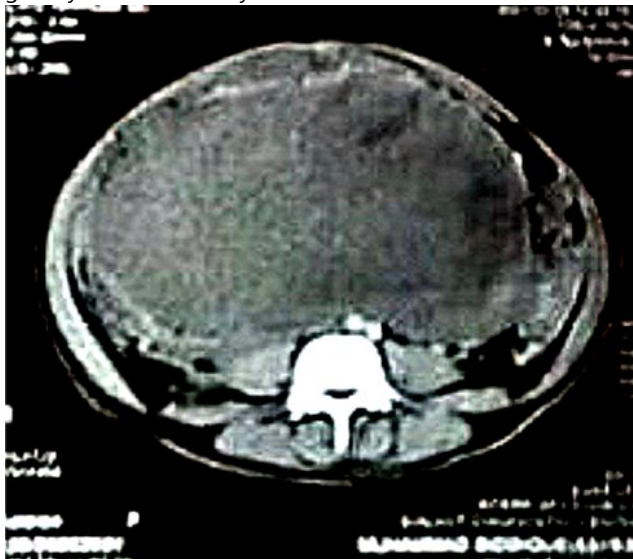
CT scan abdomen showing large retroperitoneal tumor displacing bowel loops
